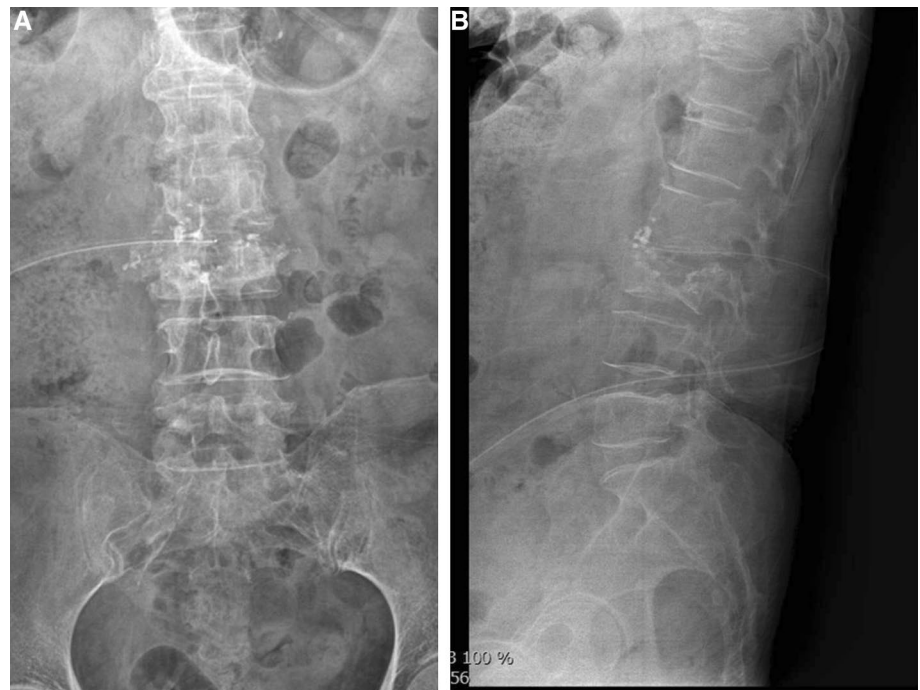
Spontaneous fusion between L2 and L3 body was observed by a anteroposterior, b flexion lateral radiograph and c extension lateral radiograph at 5 months after surgery
